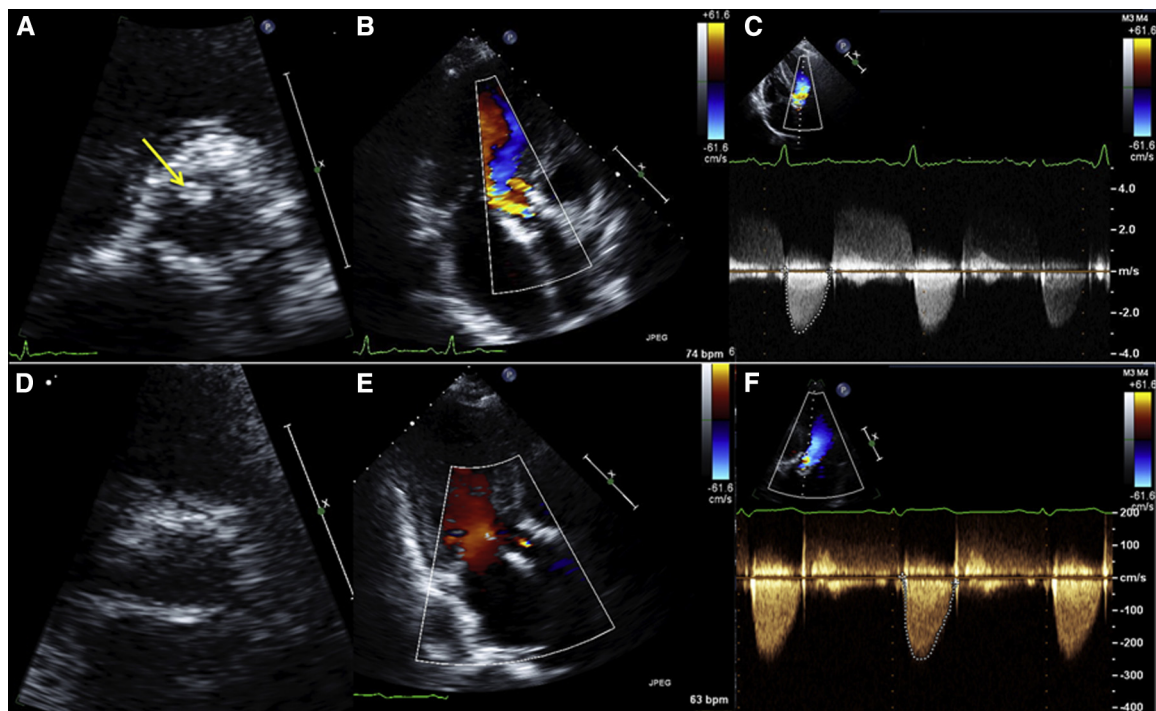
TTE showing 0.8×0.5 -cm supravulvar thrombus (yellow arrow) on bioprosthetic SAPIEN XT (Edwards Lifesciences, Irvine, Calif) valve in parasternal short-axis view (A). TTE with color Doppler during diastole in apical long-axis view demonstrating associated aortic insufficiency (B). TTE with continuous-wave Doppler in apical long-axis view demonstrating mild-moderate aortic insufficiency and increased velocity across the valve (C, peak velocity of 3.3 m/s and peak and mean gradients of 42 and 22 mm Hg, respectively). Correlative TTE images from 1 year previously (3 years post-TAVR) demonstrating the lack of thrombus, valve dysfunction, and lower transvalvular peak velocity and gradients (D-F).
